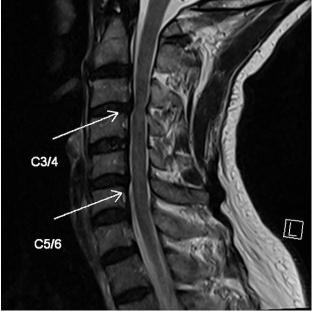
Sagittal view of cervical plain magnetic resonance imaging. Posterior disc bulge at C3/4 and C5/6 is noted, causing mild canal stenosis.
